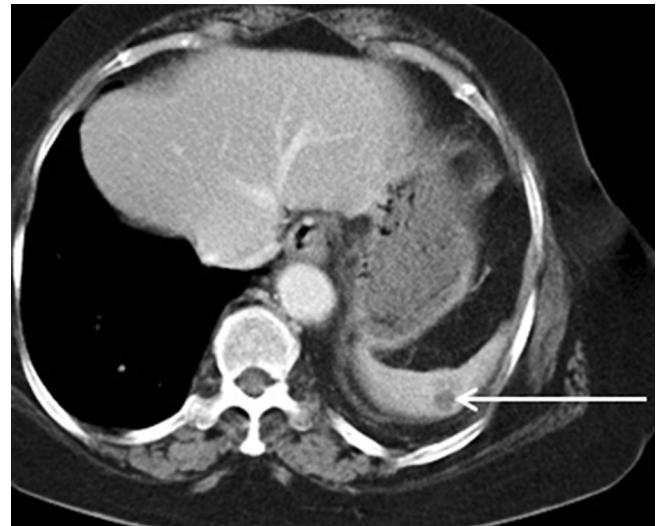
Splenic tuberculosis. 67-year-old man with abdominal pain. Axial, contrast-enhanced CT image shows a low attenuation splenic lesion (arrow); there were multiple similar, smaller lesions in other areas of the spleen. The patient had known tuberculosis, and the lesions improved after therapy. Image courtesy of Nilesh Gupta, MBBS, DNB, (Raipur, India).
